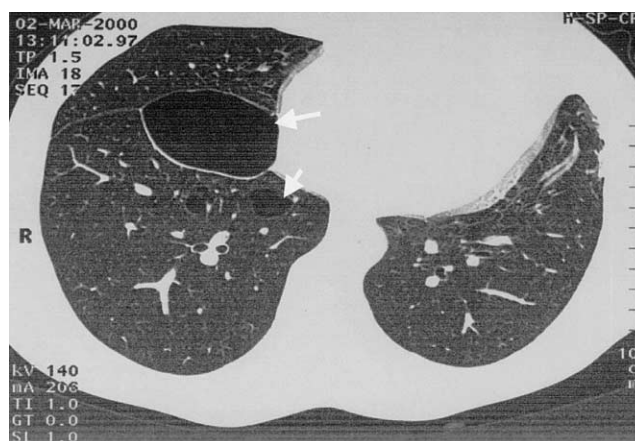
HRCT scan of the index patient, who experienced recurrent episodes of PSP. Numerous bullae are visible, seen as clear, black areas. The two largest bullae are indicated with arrows.
